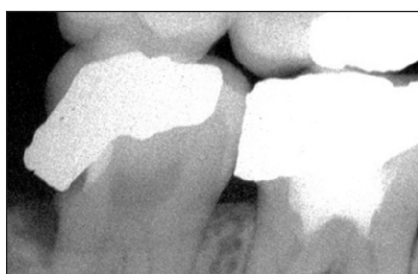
Preoperative radiographic image of teeth #18 and #19. Extensive overhang existed in both the distal portion of the restorations.
